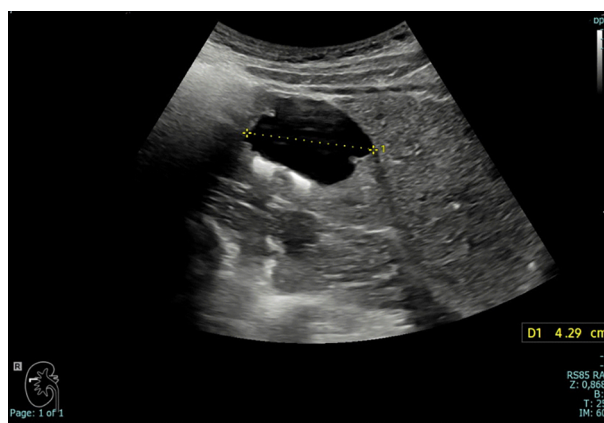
Ultrasound image showing a complex, predominantly anechoic cystic mass in the right kidney, measuring 4.30 cm.
